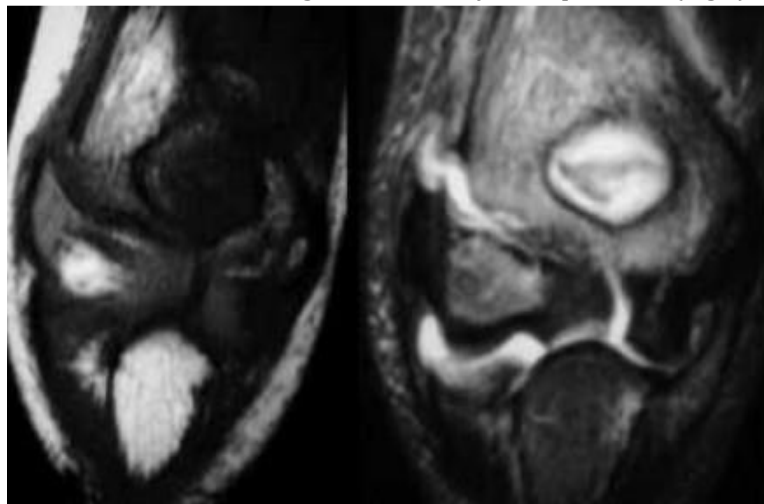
MRI of lateral condyle fracture. Milch II and unstable elbow. T2 image with fat saturation on the right shows cartilaginous fracture ⁽³⁶⁾
